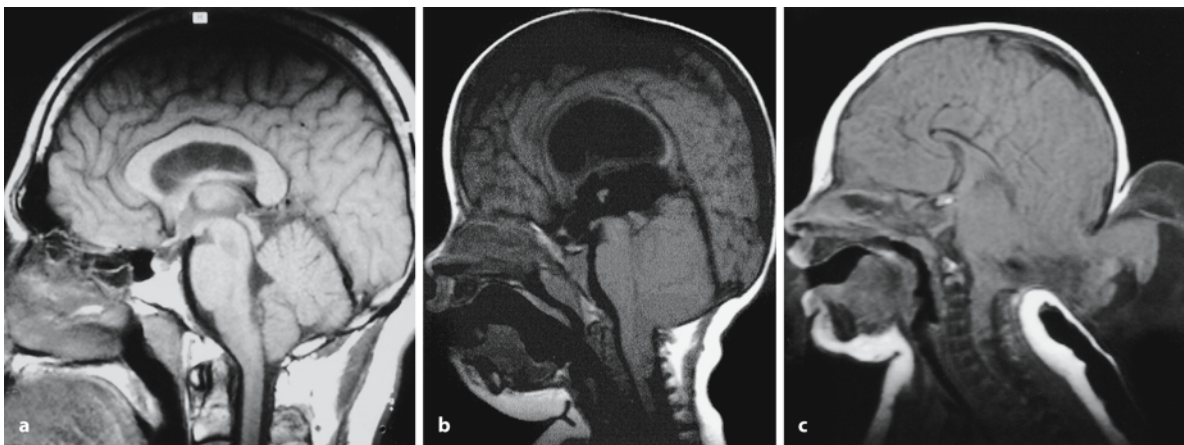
Chiari malformations: MRI of Chiari I (a), Chiari II (b) and Chiari III (c) malformations (kindly provided by Henk O.M. Thijssen, Department of Radiology, Radboud University Nijmegen Medical Centre)
